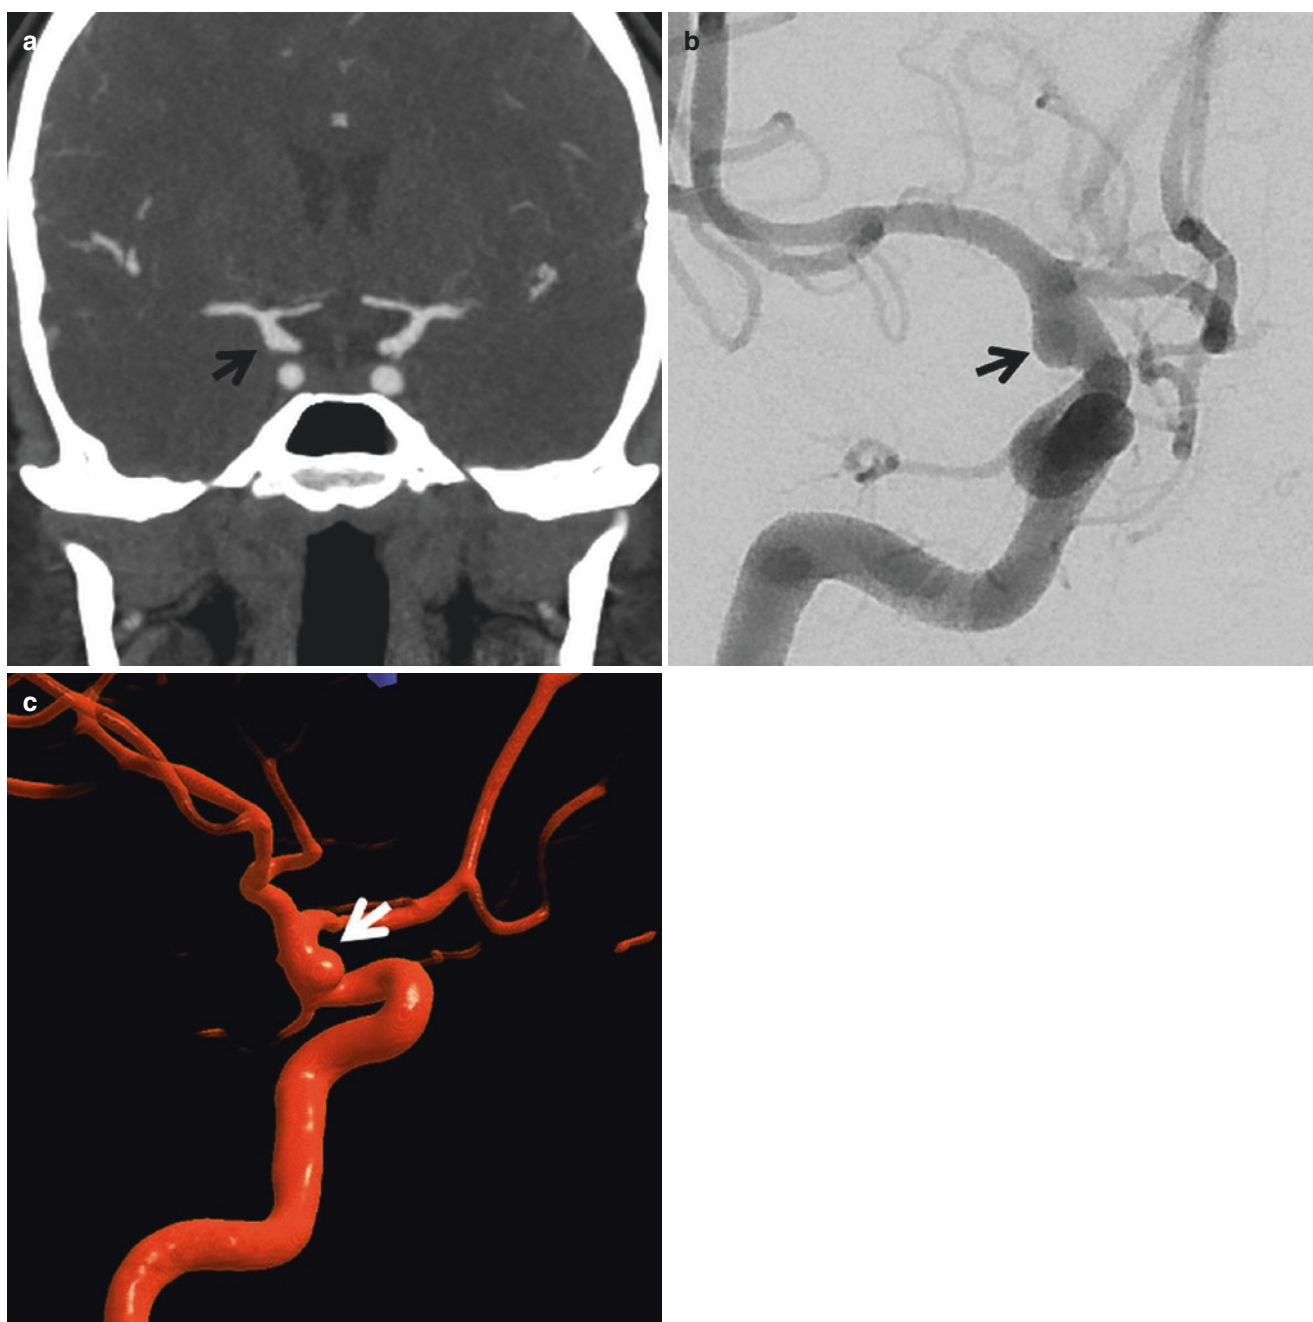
Blood-blister aneurysm. (a) Coronal CTA shows a broad-based contour bulge of the right supraclinoid ICA (*arrow*). (b) AP DSA shows similar finding. (c) 3D rotational angiography better demonstrates the blister aneurysm at the superior surface of the right ICA
